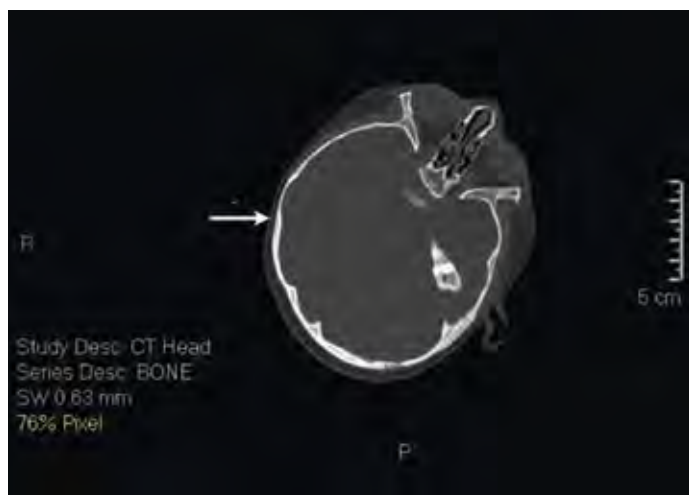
CT scans of the same patient seen in figure 2. Left: an axial bone window CT scan showing an absent right lambdoid suture (arrow). Right: A 3D CT scan showing the absent right lambdoid suture.
